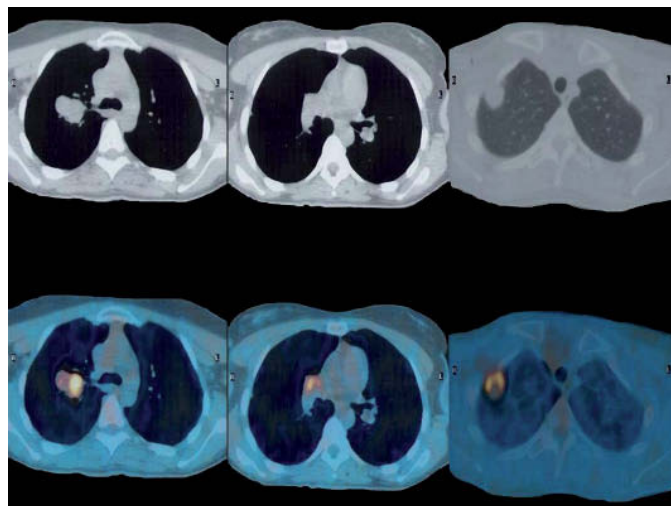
Positron emission tomography-computed tomography scan showing pulmonary lesions.
